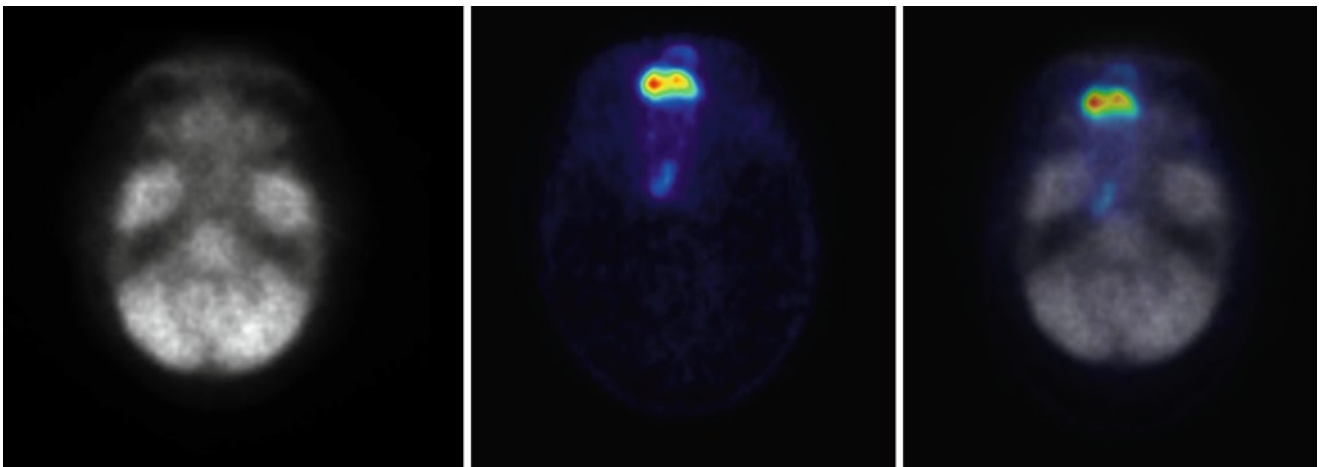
Left:* FDG image 60 min after tracer application in a patient with a malignant histiocytoma. Low FDG accumulation due to a low tumor metabolism. *Middle:* Image 60 min following FLT injection.
